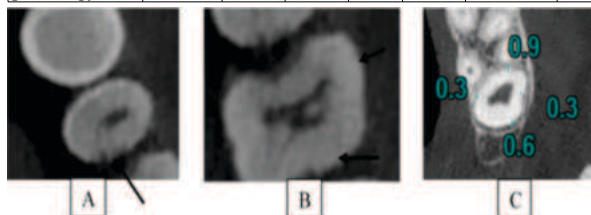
CBCT sections (axial) shows AI ((A) Hypomaturation, (B) Hypocalcification, (C) Hypoplastic)
